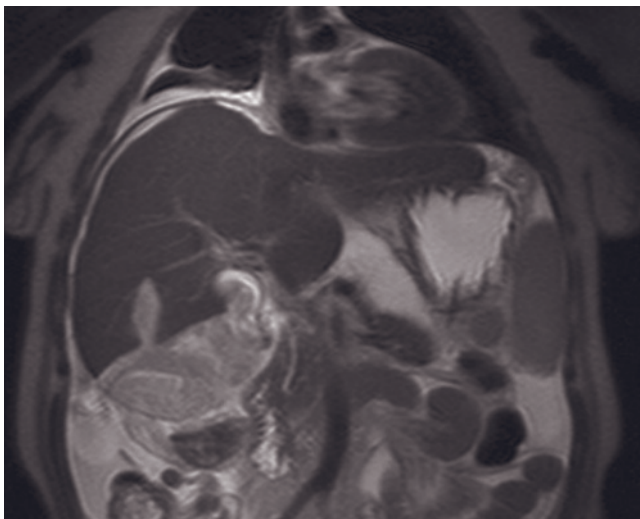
Hematoma in recipient. Coronal SGE (a) and transverse immediate postgadolinium SGE (b) images in a patient who is the recipient of a right hepatic lobe transplant. There is a perihepatic fluid collection (arrows, a, b) that demonstrates a high-signal peripheral rim on noncontrast T1-weighted images (a), consistent with hematoma.
